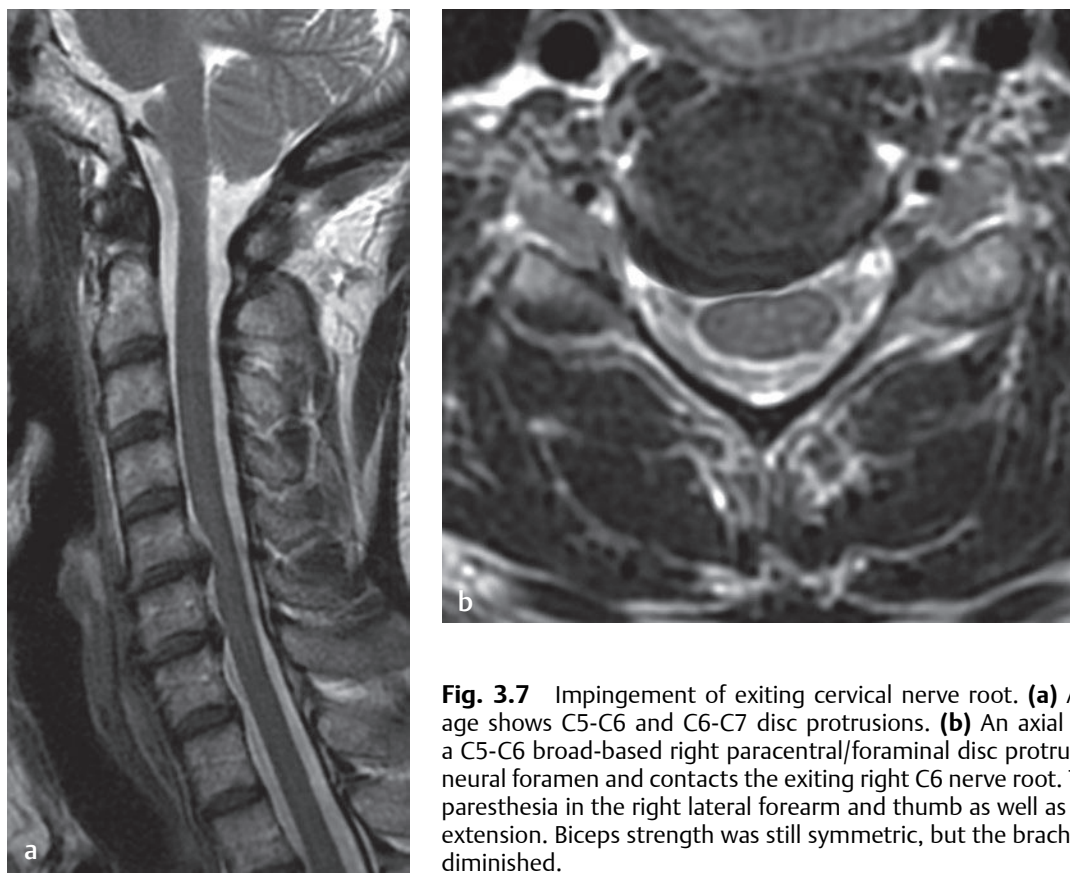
Impingement of exiting cervical nerve root. (a) A sagittal T2-weighted image shows C5-C6 and C6-C7 disc protrusions. (b) An axial T2-weighted image shows a C5-C6 broad-based right paracentral/foraminal disc protrusion that narrows the right neural foramen and contacts the exiting right C6 nerve root. This patient presented with paresthesia in the right lateral forearm and thumb as well as subtle weakness with wrist extension. Biceps strength was still symmetric, but the brachioradialis reflex was slightly diminished.
